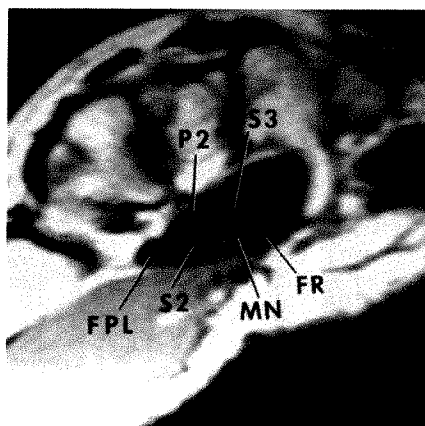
MR image (600/20) of flexed wrist shows volar tendon shift with median nerve remaining anteriorly between sublimis tendons 2 and 3 and flexor retinaculum. (See key for abbreviations.)
